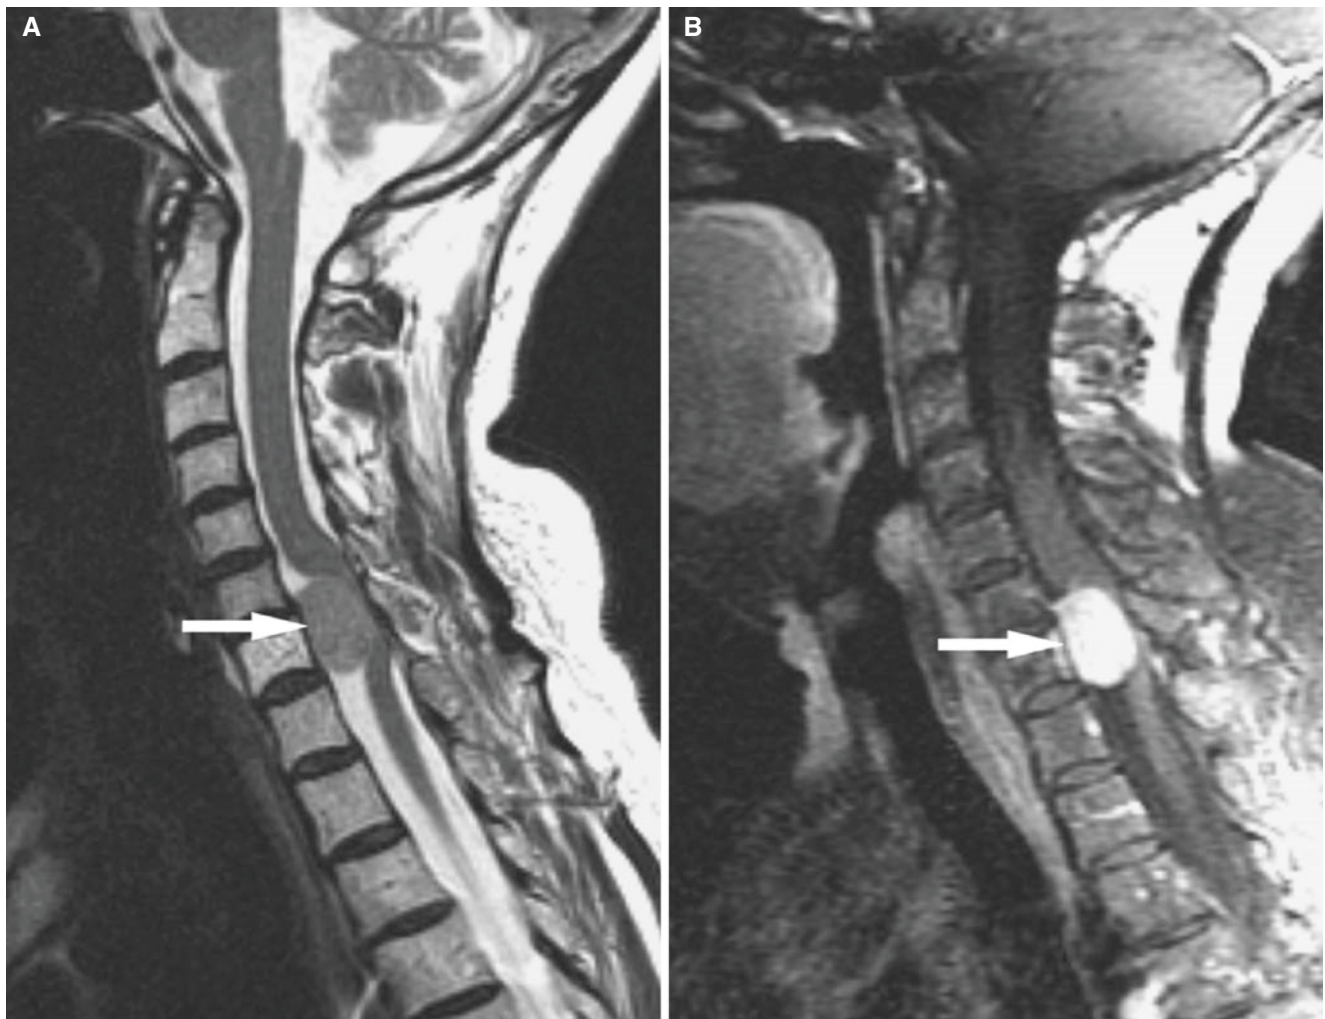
Meningioma; 67-year-old woman with progressive weakness in both lower extremities and pain in both arms. Remote history of breast cancer. (A) Sagittal T2-weighted MRI shows well-defined mass
